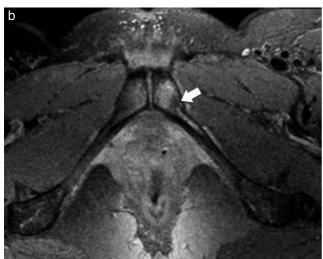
Fracture and levator ani tear in a 34-year-old woman after a 'high-risk' vaginal delivery. Axial proton density magnetic resonance image (a) and proton density-weighted image with fat saturation (b) show focal-intense left inferior pubic ramus bone marrow edema and cortical fracture (arrows).
